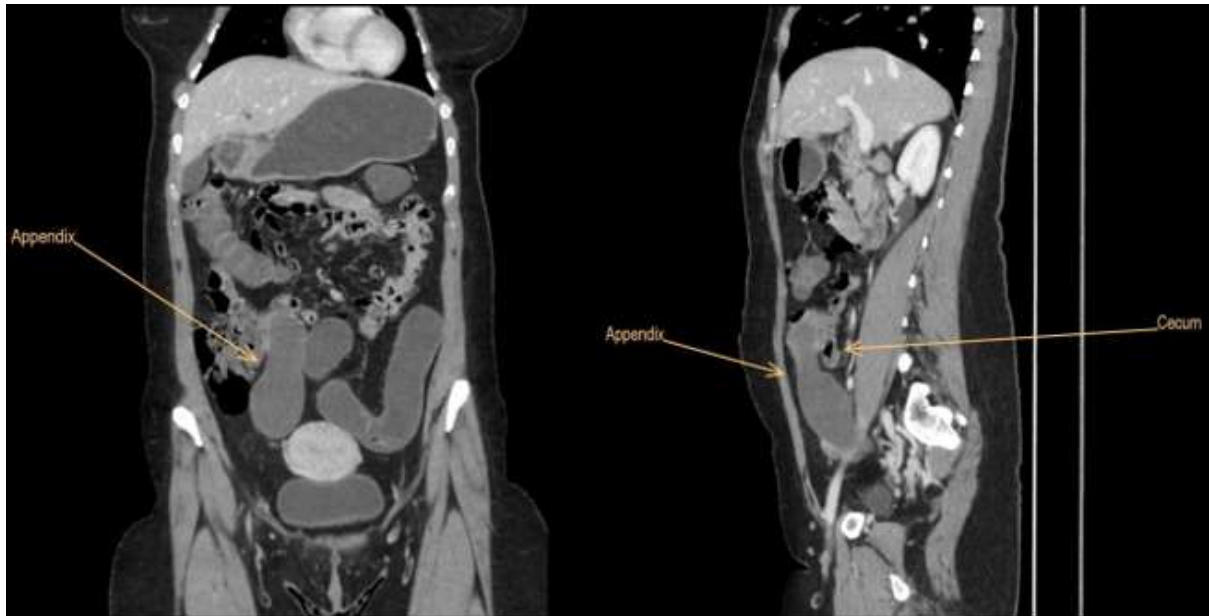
CT images of the mucocele appendix in relation to the cecum
